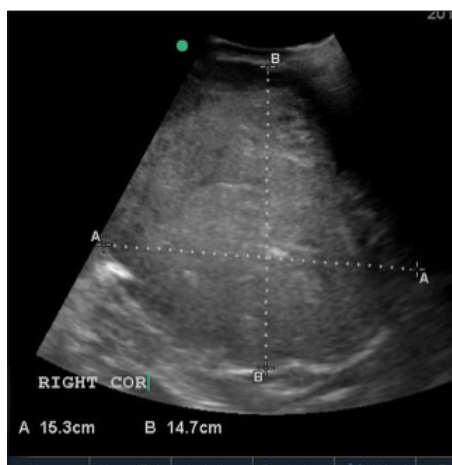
Ultrasound scan showing a mass arising from the right kidney.
